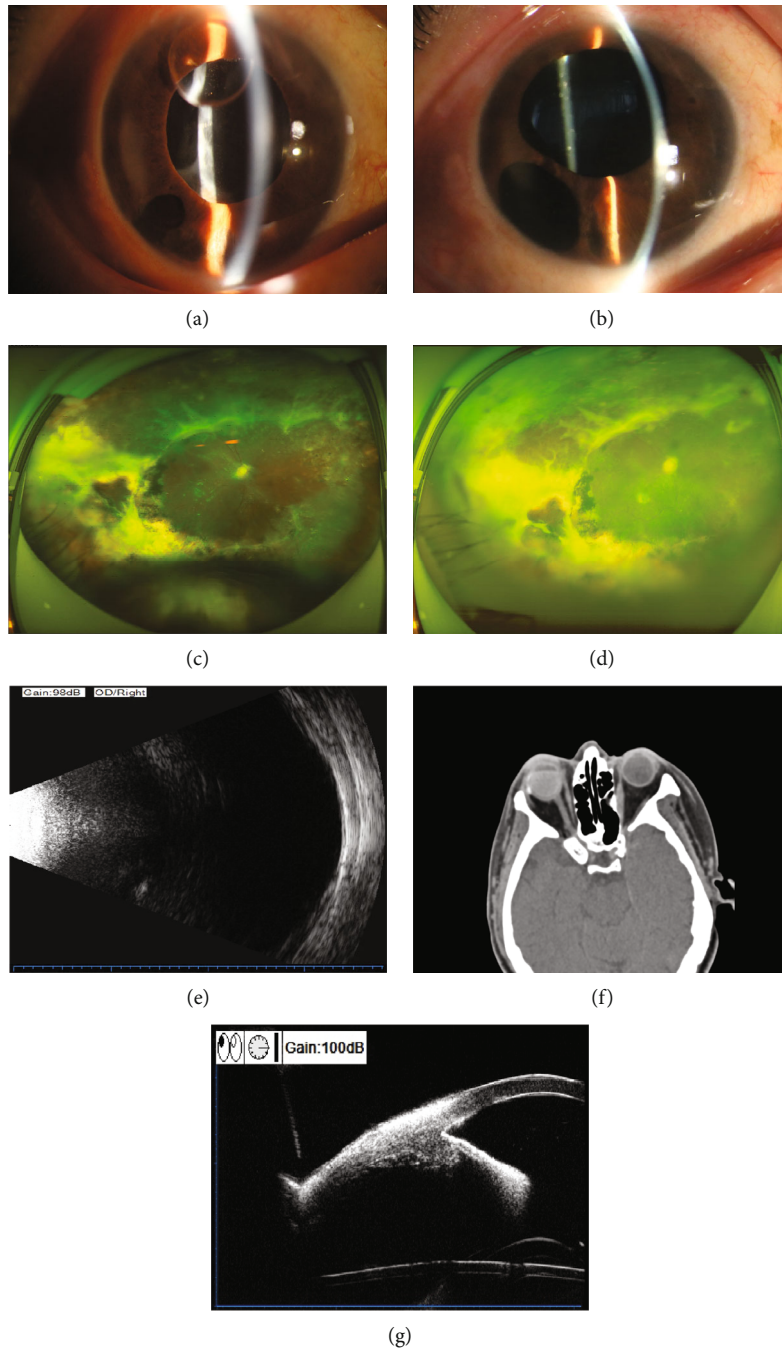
Examination results before and 12 months after FCVB implantation in the SO-dependent eye. (a) Preoperative anterior segment photography indicated that the vitreous cavity was filled with SO, and the SO was moved into the anterior chamber. The cornea was clear, the pupil was dilated but had upward deviation, and the lens was absent. (b) Anterior segment photography at 12 months after surgery revealed that the cornea was clear, the pupil was still round but with upward deviation, and iris root incision was unobstructed. (c) Preoperative fundus photography showed extensive degeneration, detachment, and proliferation of peripheral retina lesions. (d) Fundus photography 12 months after surgery indicated that the retina was flat. (e) B-ultrasound eye at 12 months after surgery showed the reflection of the posterior wall of the eyeball as smooth and the FCVB morphology as intact. (f) Postoperative orbital computed tomography displayed that the appearance of eyeball was normal, the FCVB position was correct, and the SO was filled in place. (g) UBM at 12 months after surgery showed approximately normal anterior chamber depth, with opened chamber angle and smooth front surface of FCVB.
